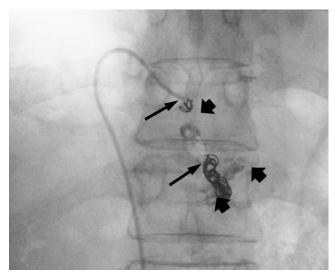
Plain X-ray film after all embolization procedures shows that the portal aneurysm and the IPSVS are completely occupied by the radiopaque NBCA-Lipiodol mixture (arrowheads) and microcoils (arrows).
